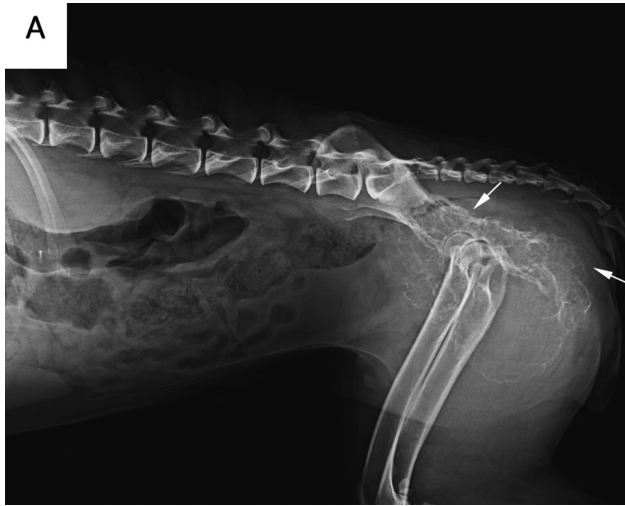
Same radiographic images as in Figure 1. Notice the bilateral severe bony lysis of the ilia, ischia, and pubes. The bony lesion has an atypical appearance, which symmetrically involves the entire pelvic region; the iliac wings, sacral and lumbar vertebral bodies, caudal vertebrae, and femoral heads and diaphyses appear lesion free. Moderate to severe soft tissue swelling is apparent along the pelvic limbs. A—Notice the lack of normal cortical contours in the caudal aspects of the ilia, ischia, and pubic bones (arrows). B—Notice that bone loss begins at approximately the level of the middle portion of the ilia (arrows).
